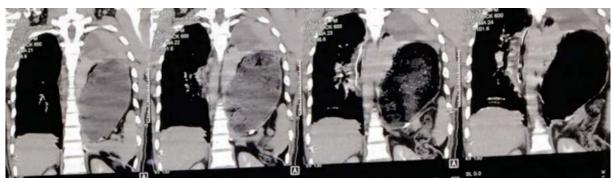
the intra-abdominal content herniated into the thorax shown in coronal view of the thoracoabdominal computed tomography scan of the patient.
